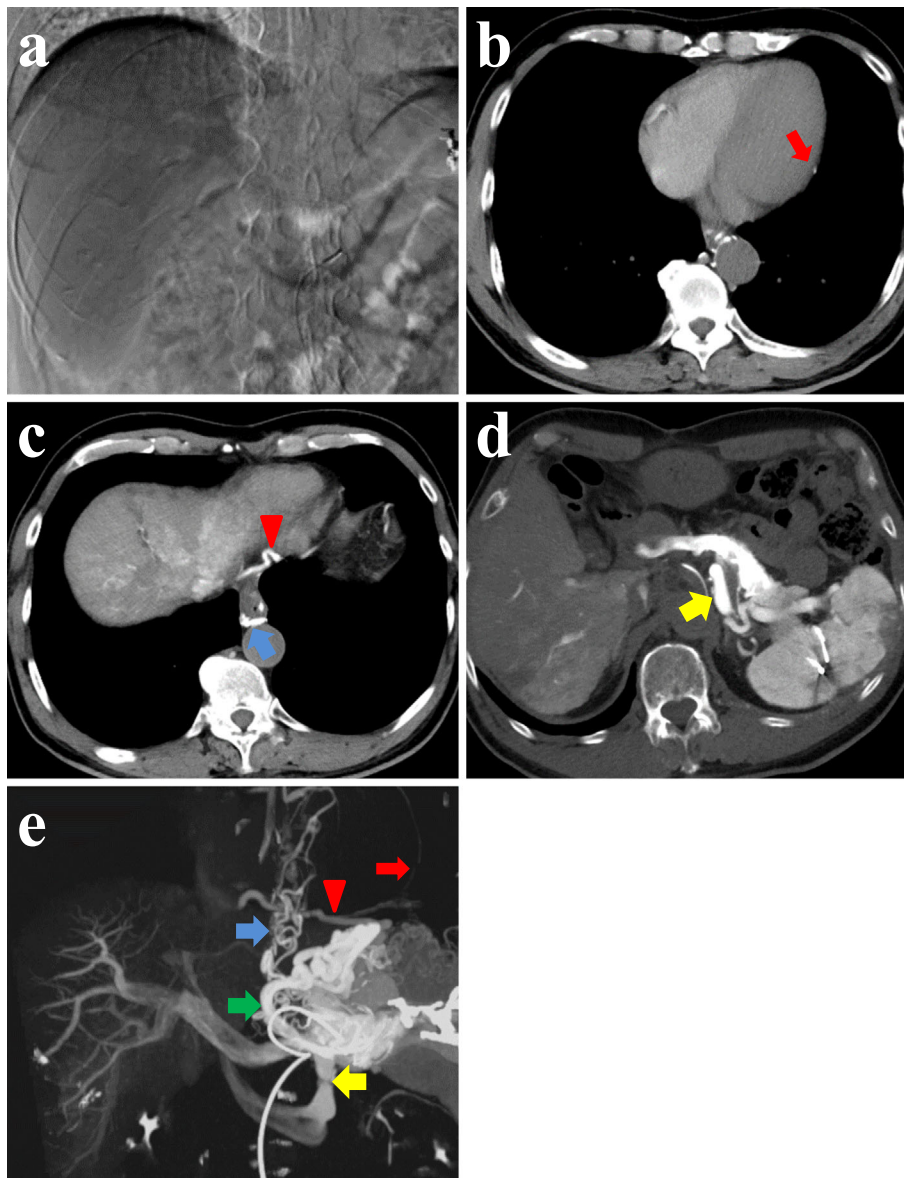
The portal phase of superior mesenteric angiography showed that portal flow was hepatopetal, and the IGVs were not visualized (a). CT of splenic arterial portography showed that the efferent veins were the pericardiophrenic vein (red arrow) (b), inferior phrenic vein (red triangle), para-esophageal vein (blue arrow) (c), and left renal vein (yellow arrow), which was the main drainage route afferent vein (d). CT also showed that the short gastric vein (green arrow) was the afferent vein (e).
